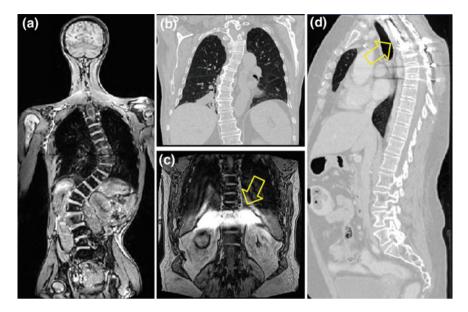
Challenges of vertebrae labeling in clinical cases. a A MR scan of a scoliosis patient. b A CT scan of a scoliosis patient. c A MR scan with folding artifact. d A CT scan with metal implant
